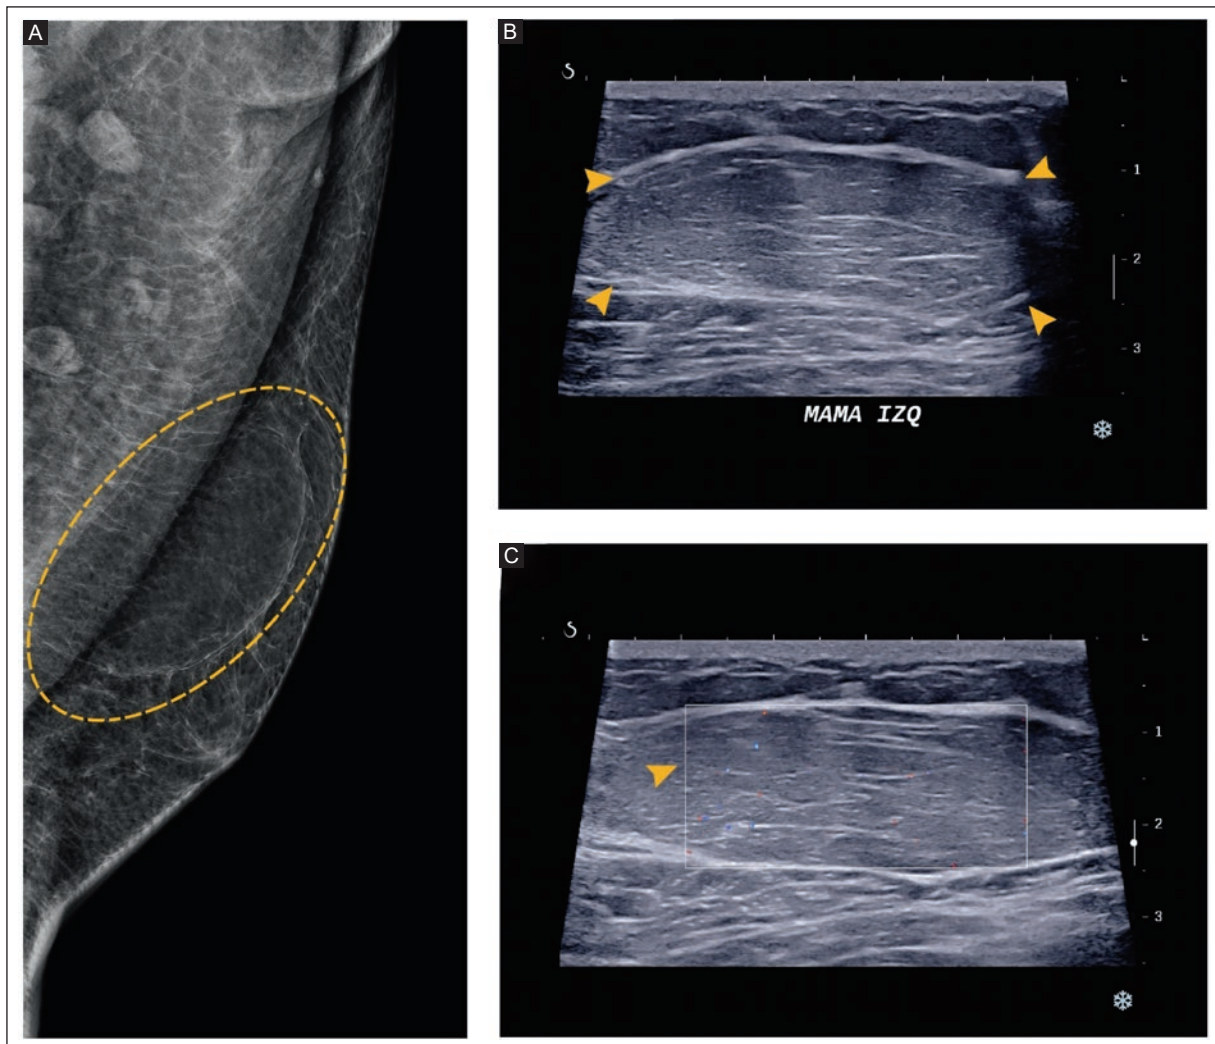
A 34-year-old man with a slow-growing palpable lump in the left breast. A: MLO mammography projection of the left breast, upper quadrants, middle to posterior third, shows an oval, circumscribed, fatty mass (dashed circle). B: grayscale US shows a circumscribed, oval isoechoic fatty tissue mass (arrowheads) without posterior acoustic findings. C: Doppler US shows an avascular mass (arrowhead). BI-RADS 2. The diagnosis was lipoma.
